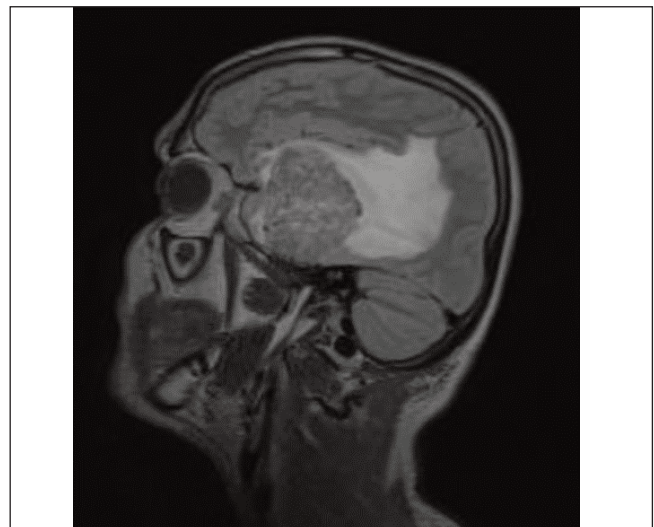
MRI brain FLAIR image sagittal section of the same patient showing significant peri-lesional oedema extending to the frontal, temporal and parietal lobes. Such a finding in dural based lesions otherwise suspected to be meningiomas, should raise the suspicion of HPC.
